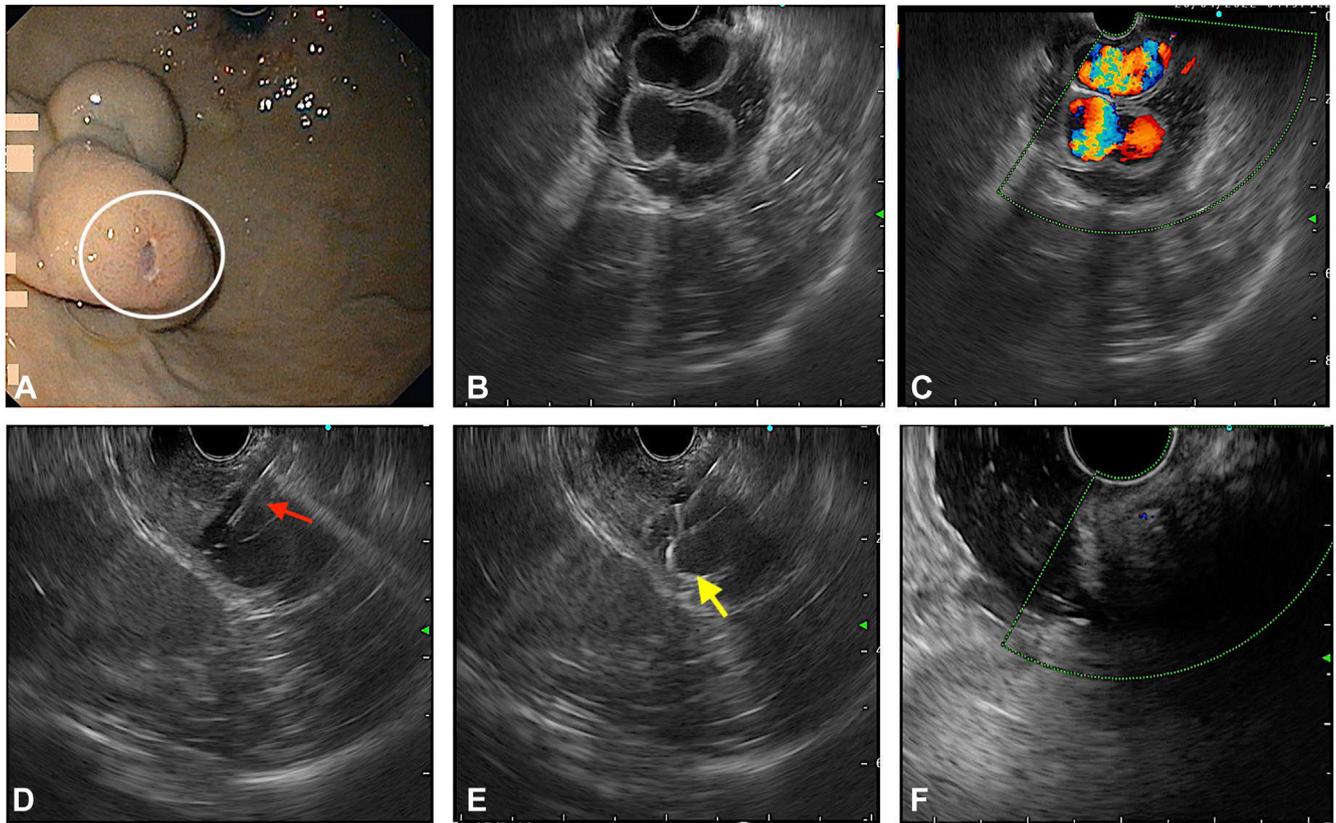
EUS-guided embolization of the gastric varices via transesophageal route. A, Endoscopic view of isolated gastric varices with stigmata of recent bleed on the varix (*white circle*). B, EUS image of large gastric varices. C, Color Doppler revealed strong Doppler flow within the varix. D, Varix was punctured with a 19-gauge needle (*red arrow*) under EUS guidance. E, Coils (hyperechoic rings, *yellow arrow*) were deployed under EUS guidance. F, Complete disappearance of Doppler flow within the varix seen after coil–glue injection.
